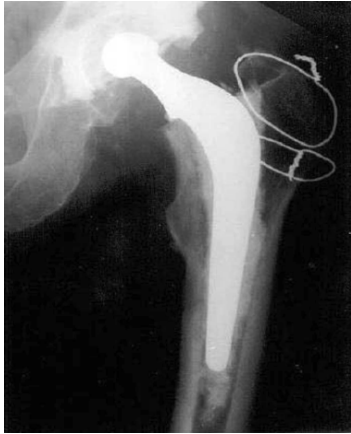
Radiograph of Total Hip Prosthesis. (Courtesy: reproduced with the kind permission of Injury/Elsevier)
